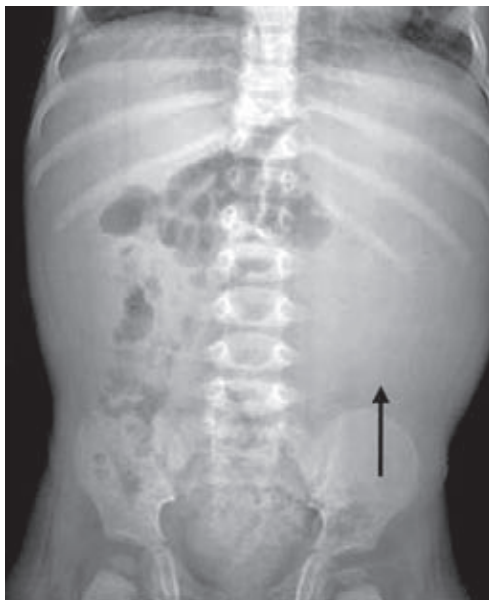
Left sided Wilms' tumour. Plain abdominal radiograph shows a left side soft tissue mass (arrow)
